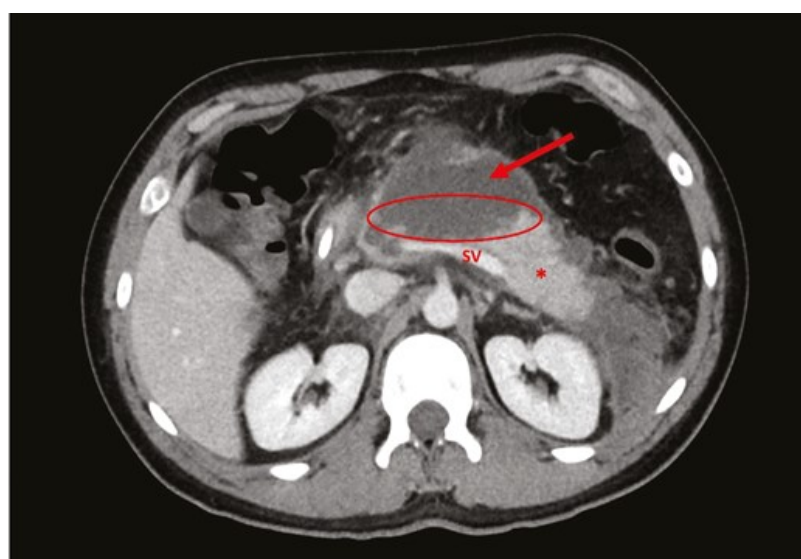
Contrast-enhanced computed tomography 2 weeks after symptom onset, demonstrating pancreatic parenchymal necrosis of the neck and body of the gland (oval), compared to normal enhancement of the tail of the pancreas (*). Note the development of peripancreatic necrosis anterior to the gland and the development of an acute necrotic collection (arrow). SV, splenic vein.
